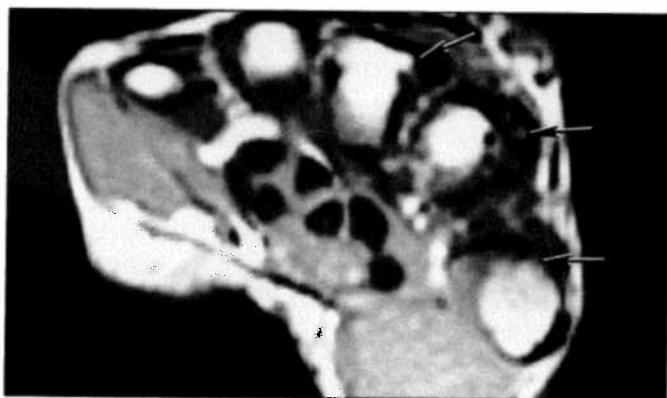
A) Magnetic resonance imaging with T1; B) proton density; C) T2 weighted sequences. The majority of the marrow fat is preserved in the metacarpals; however, abnormal low signal lesions were detected on T1 that increased in intensity on both proton density and T2-weighted images in the first 3 metacarpals (arrows). All 3 appeared to have the epicenter in the cortex with only minimal marrow involvement. The same signal abnormalities were also present in the soft tissue surrounding the affected metacarpals.
